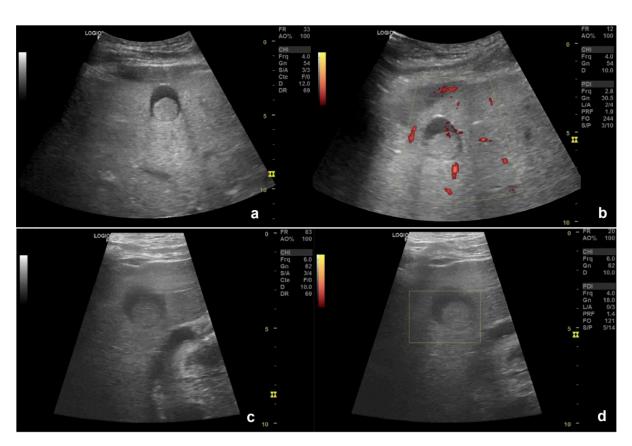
Transverse ultrasound images of the epigastric region, at low (a, b) and high frequency (c, d) in B mode (a, c) and power Doppler (b, d), showing a well-defined, unilocular aval cystic lesion, anechoic with posterior acoustic enhancement, containing heterogeneous dependent material iso-echoic to the parenchyma, without Doppler signal.
